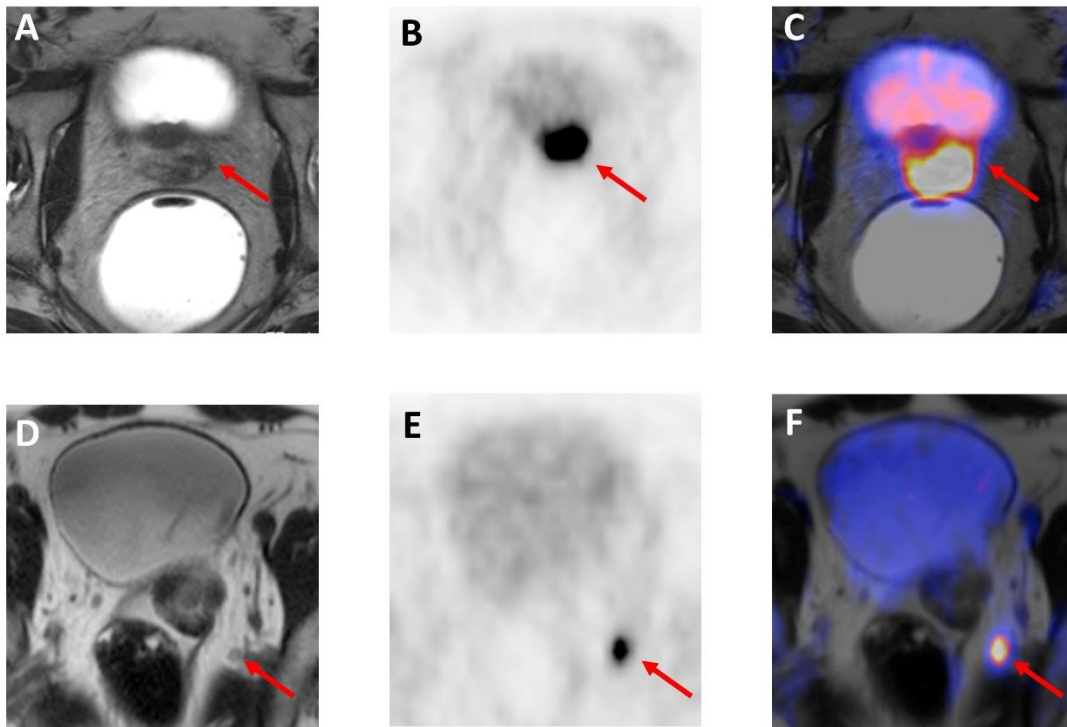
^{18}F -rhPSMA7–PET/MRI of a 66-year-old patient with primary prostate cancer (serum initial PSA (iPSA): 8.74 ng/ml and Gleason Score 8 at radical prostatectomy).
